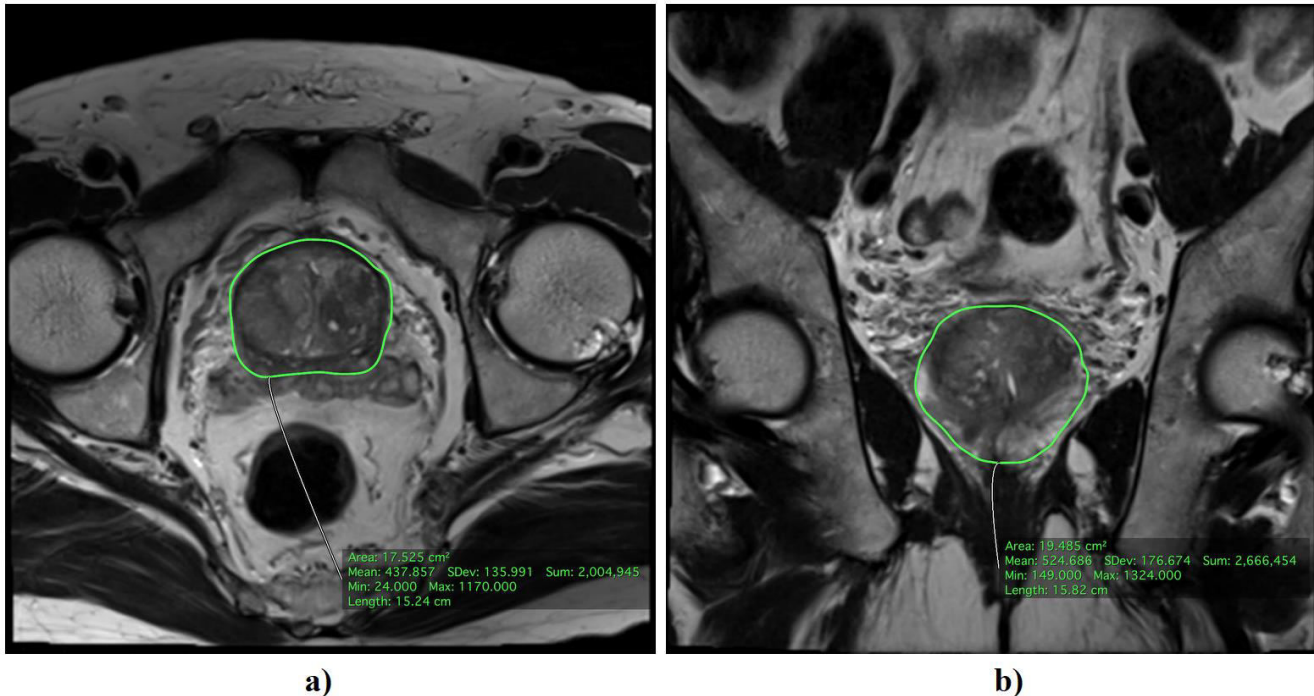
High resolution T2w MRI of PCa (a) Axial view; (b) Coronal view [21].
